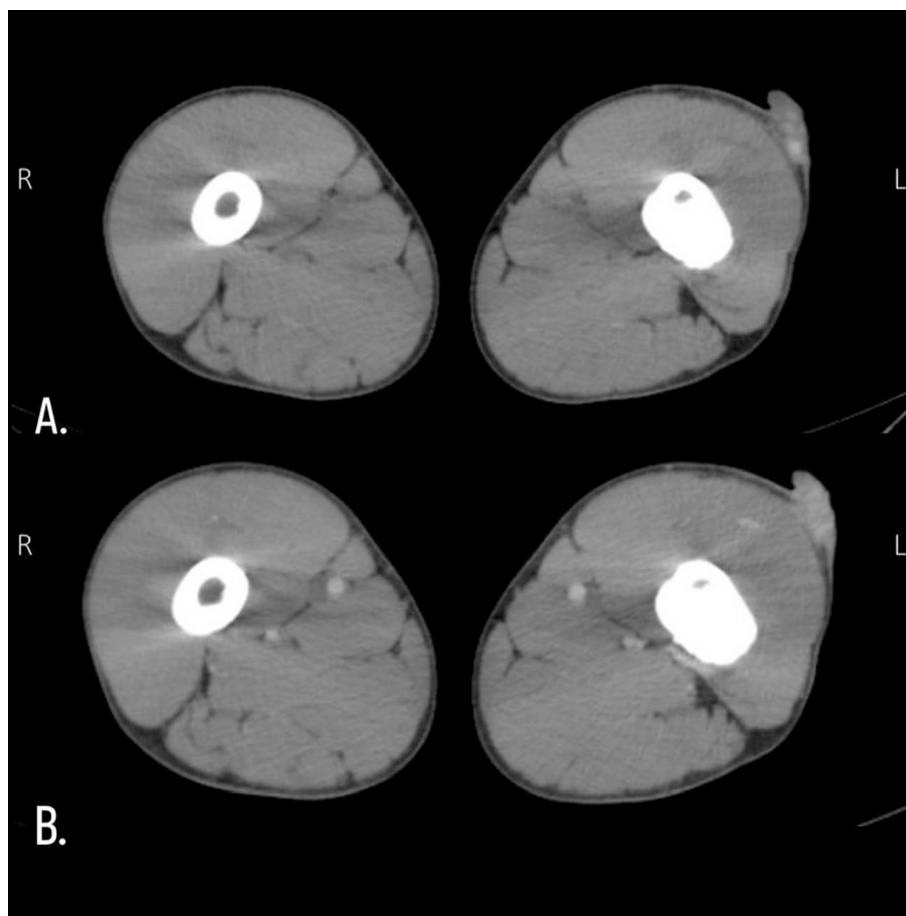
A. - Non-contrast CT imaging displaying a pilomatrix carcinoma located on the lateral aspect of the upper left thigh, notable for the presence of microcalcifications. B. - Contrast-enhanced CT scan (IV contrast) highlighting enhancement of the lesion.
